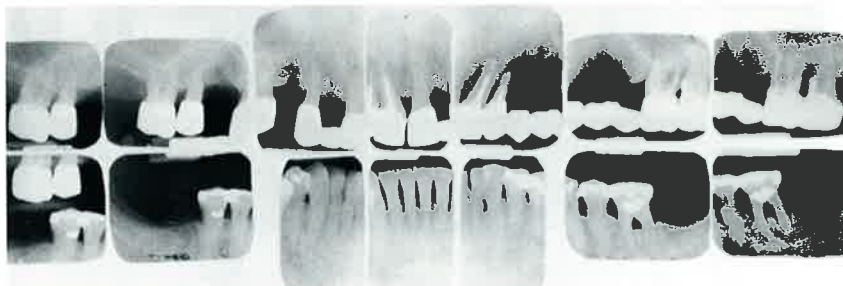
1983 periapical radiographs demonstrate periapical abscesses and advanced periodontal disease.
